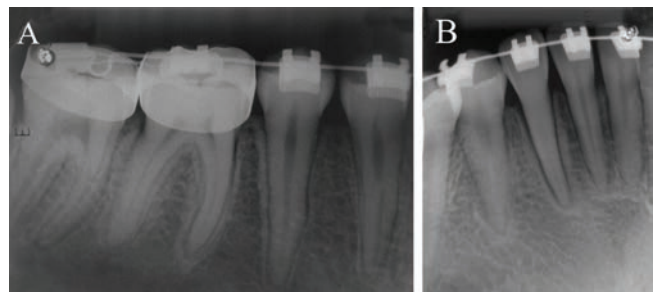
A) and B) Two and a half years follow-up. A post-treatment periapical radiograph showing complete bone formation.
